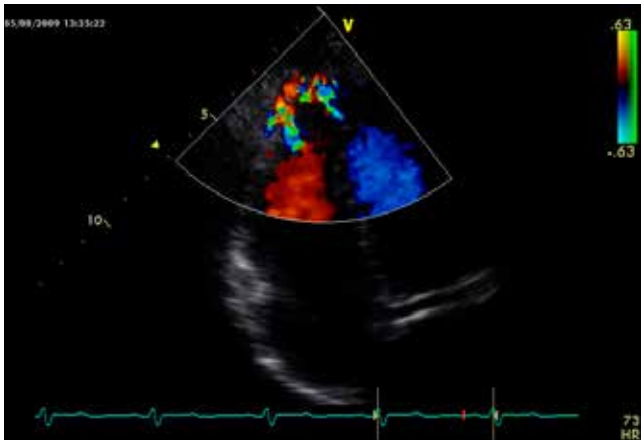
Echocardiography. Parasternal short-axis view. Colour Doppler flow demonstrating anomalous origin of the left coronary artery from the pulmonary artery. Retrograde drainage into the pulmonary artery under systemic pressure
